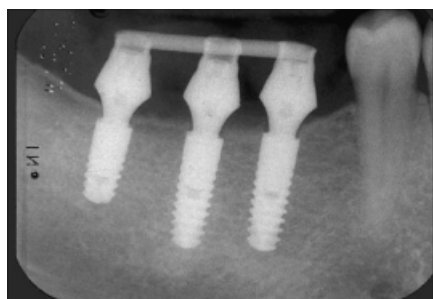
Radiographic aspect of the implant.
